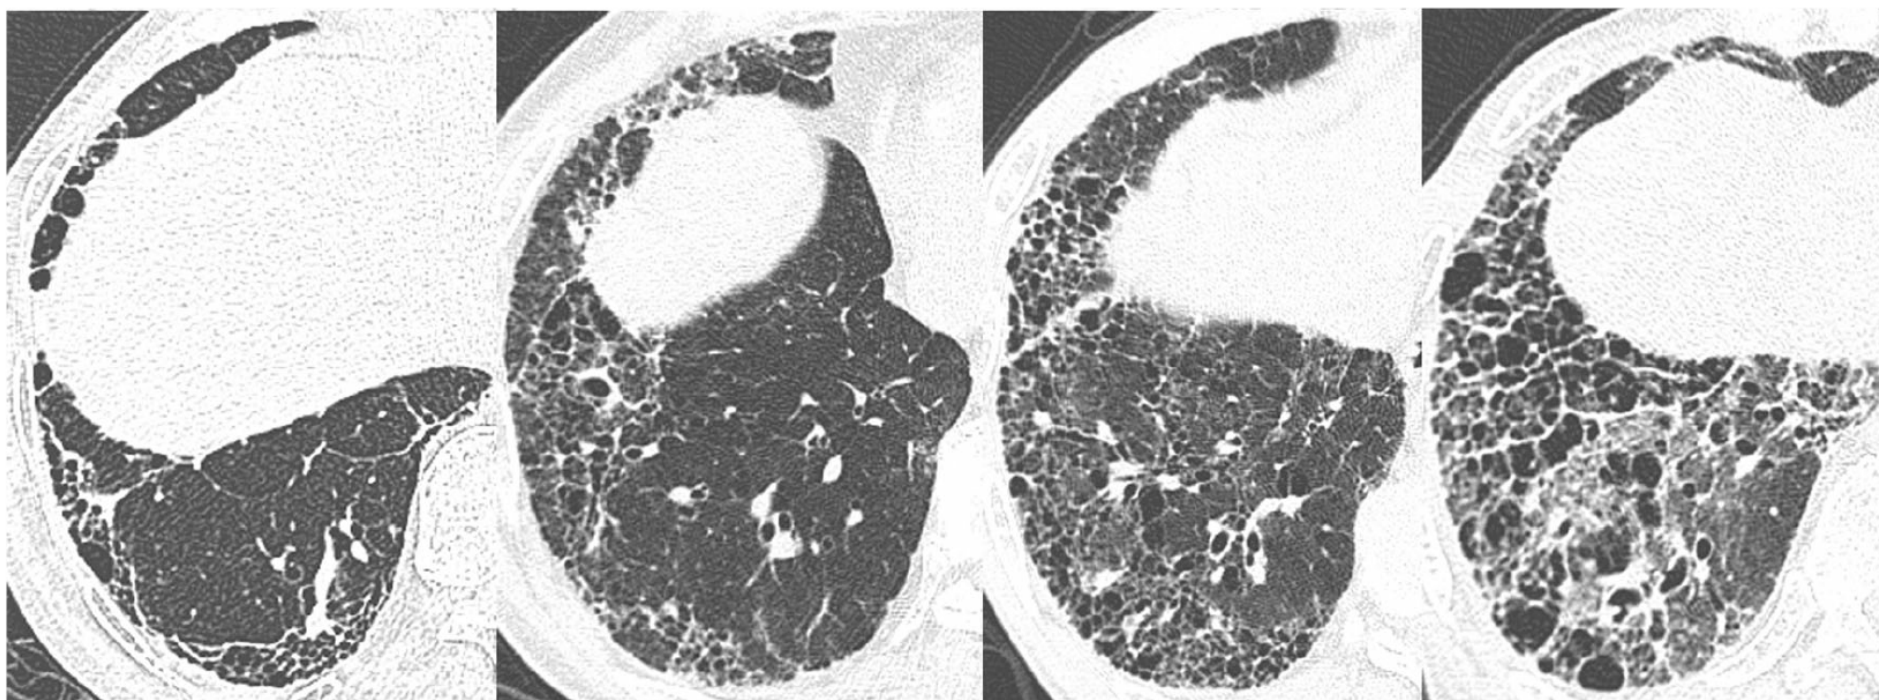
CT images of standard reference cases of honeycombing. Extent of honeycombing in lower lobes scored as 1 (mild, 1–25 %), 2 (moderate, 26–50 %), 3 (marked, 51–75 %), or 4 (severe, > 75 %)
